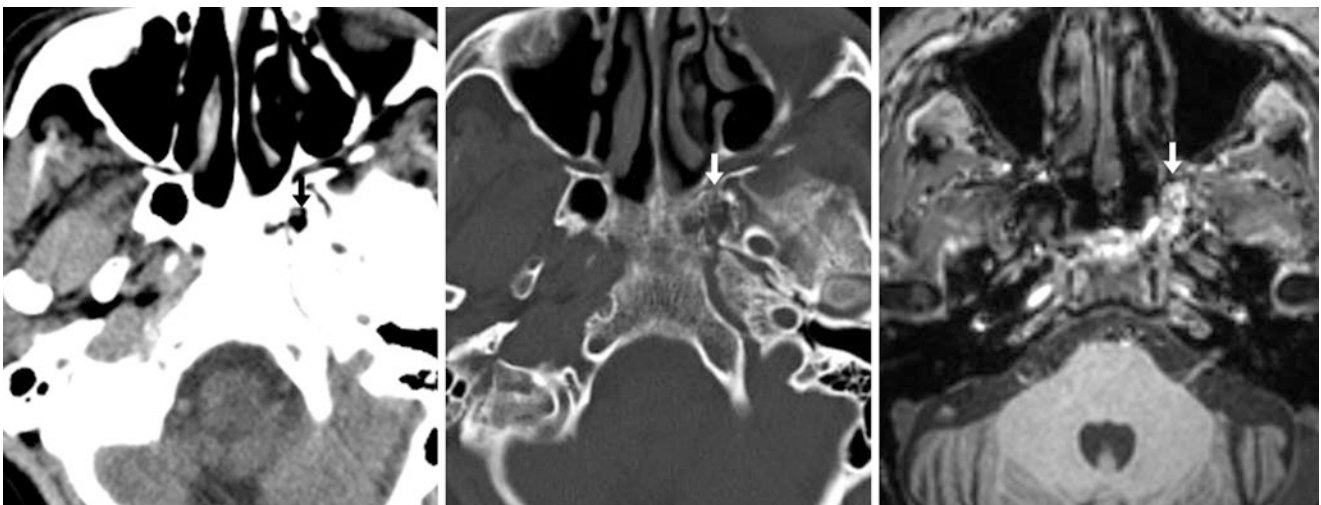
A 58 year old in whom fat density (−60 HU) was noted (*arrows*) within the left pterygoid plate on CT with soft tissue (*left*) and bone (*middle*) windows, consistent with arrested pneumatization. On 3T MRI, a gradient-echo T1WI (*right*) confirmed the bright signal of fat
